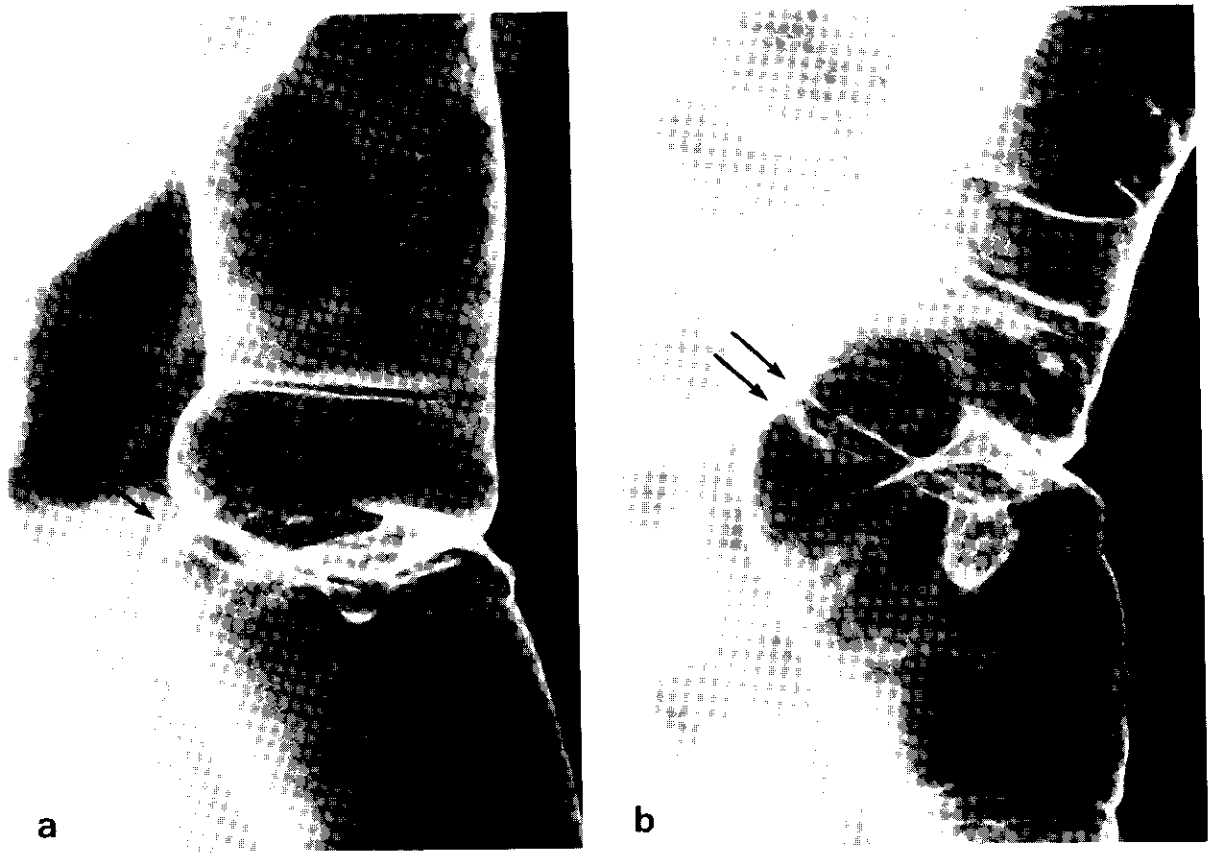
Barium enema x-rays of the descending colon of case P-J 21, III-2. (a) taken 9 August 1972 and (b) 19 October 1973. The double arrow indicates the site of anastomosis, performed in 1969. The single arrow indicates a small sessile polyp.
